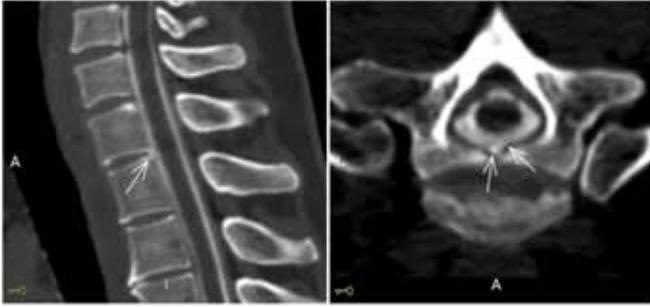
Computed tomography myelography of the cervical and thoracic spine showing epidural extravasation of contrast medium diffusely into the epidural space in the later acquisitions, from C5 to T5.
